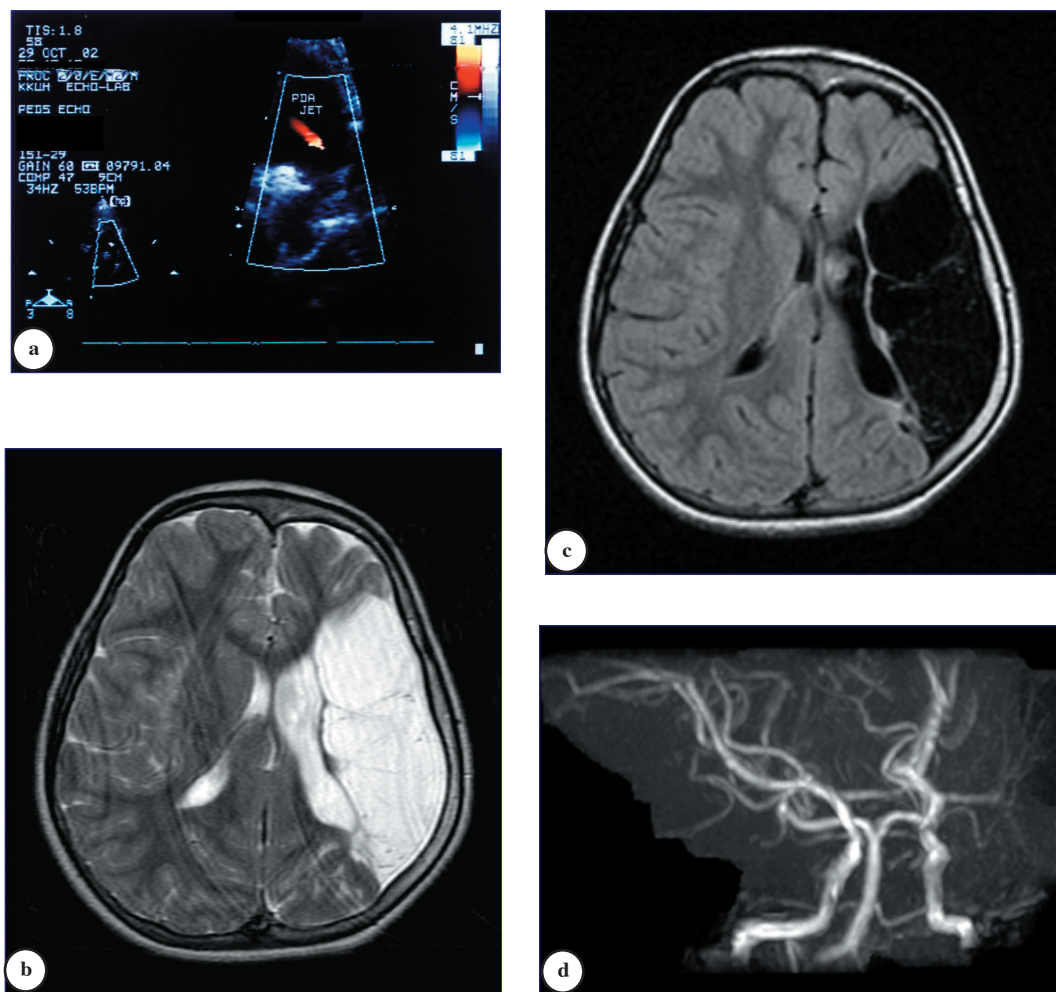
a) Ductal view of 2D-echocardiography showing small PDA with left-to-right shunting. b) Axial T2-weighted brain MR image, and c) axial FLAIR image showing small left cerebral hemisphere, large left temporo-parietal cortical and subcortical cystic encephalomalacia due to old infarction along the left middle cerebral artery territory. d) MR angiography showing attenuated caliber of the left middle cerebral artery with paucity of its branches.
